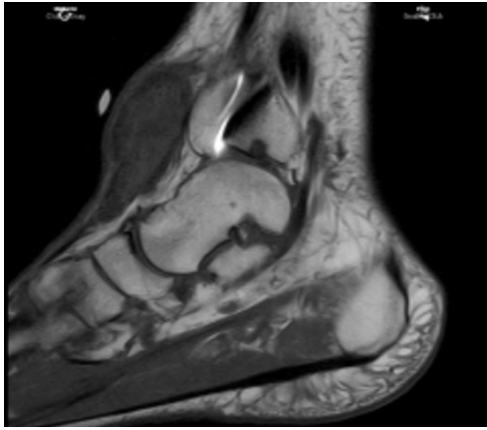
MRI of Left Lower Extremity Sagittal T1 - hypointense signal within the tumor.
